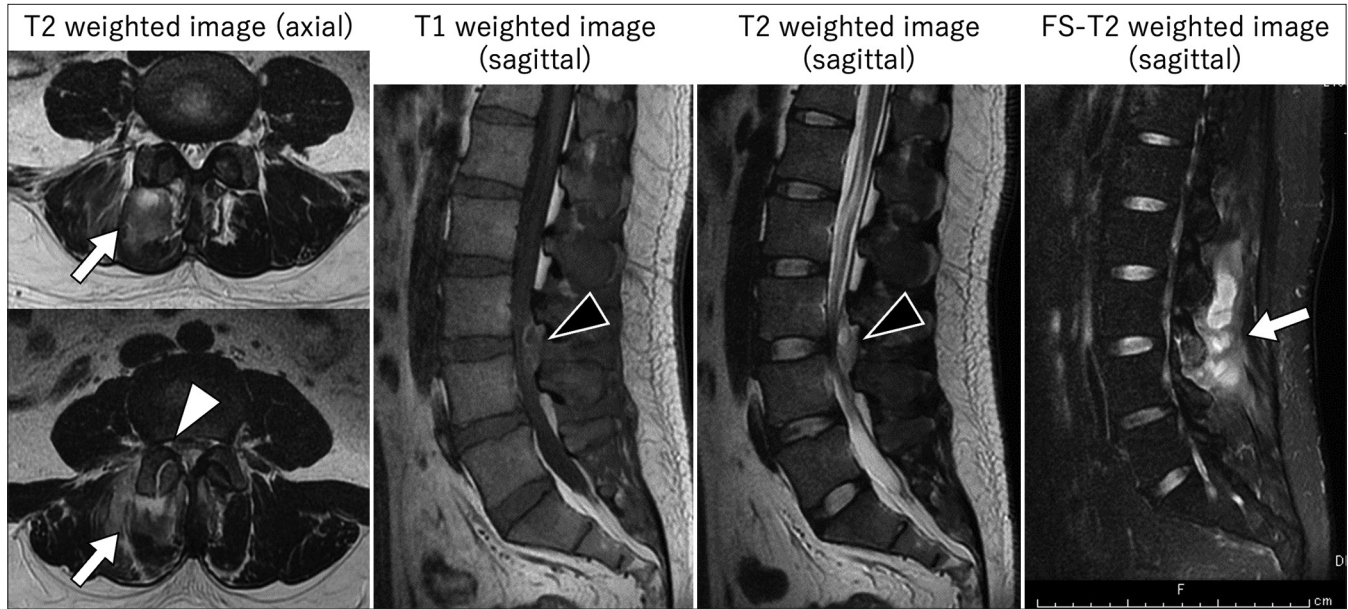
Lumbar magnetic resonance imaging showed an abnormal intensity lesion in the bilateral paraspinal muscle, especially at the right side (white arrow), in the L3/4 right facet joint (white arrow head), and epidural space (black narrow).
